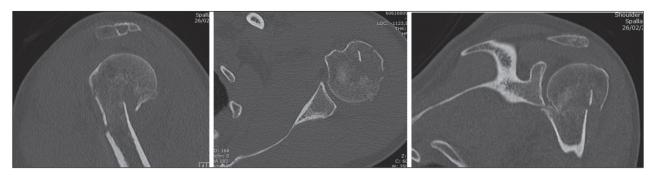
Shoulder CT scans.
